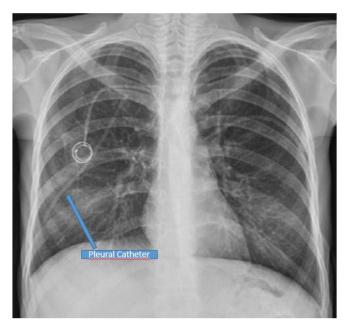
X-ray of the pleural cavity of figure 2 after pleural drainage with pleural catheter
